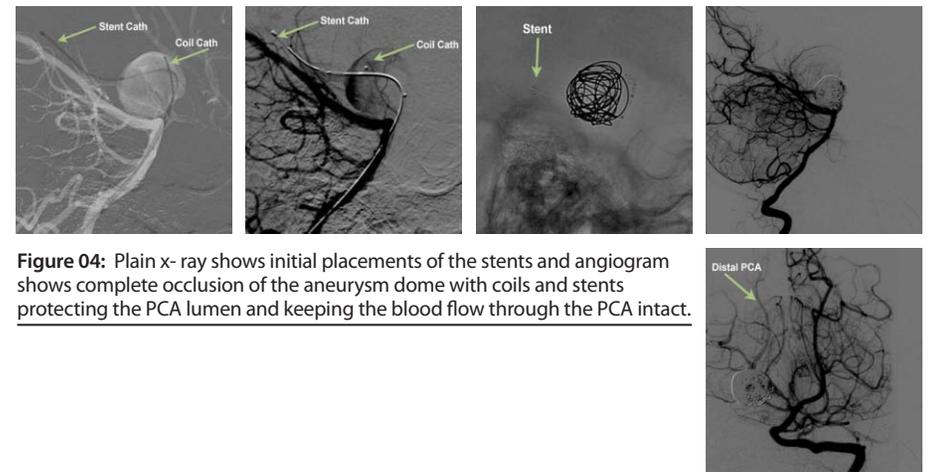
Plain x-ray shows initial placements of the stents and angiogram shows complete occlusion of the aneurysm dome with coils and stents protecting the PCA lumen and keeping the blood flow through the PCA intact.
